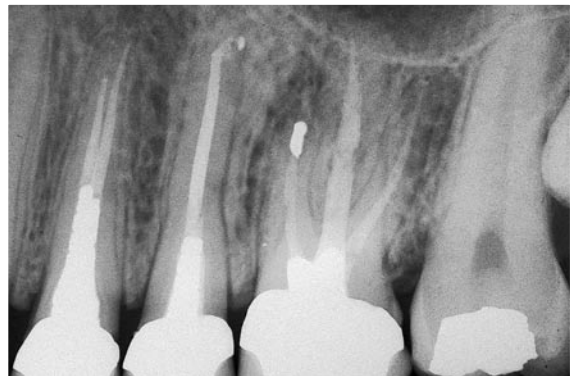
Recall radiograph two years after apicectomy with retrofilling of the two canals of the mesiobuccal root. The two fillings are joined, since the two canals communicate with one another through a thin isthmus, which has been included in the cavity for the retrofilling.
